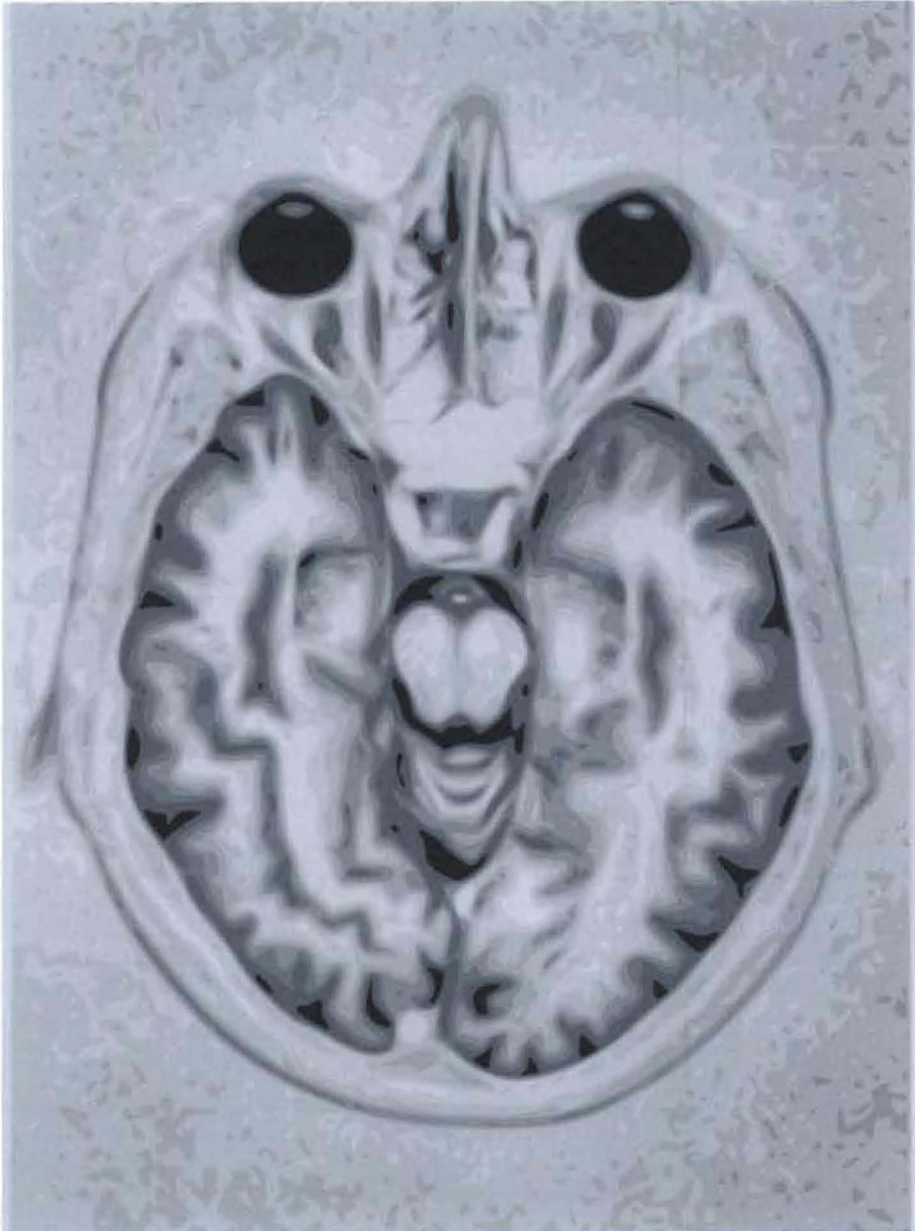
An example of an image produced using MRI. © Nevit Dilman. From Wikimedia commons: http://commons.wikimedia.org/wiki/File:Brain_Mri_nevit.svg. Used under the Creative Commons Attribution Share Alike 3.0 Unported License.
